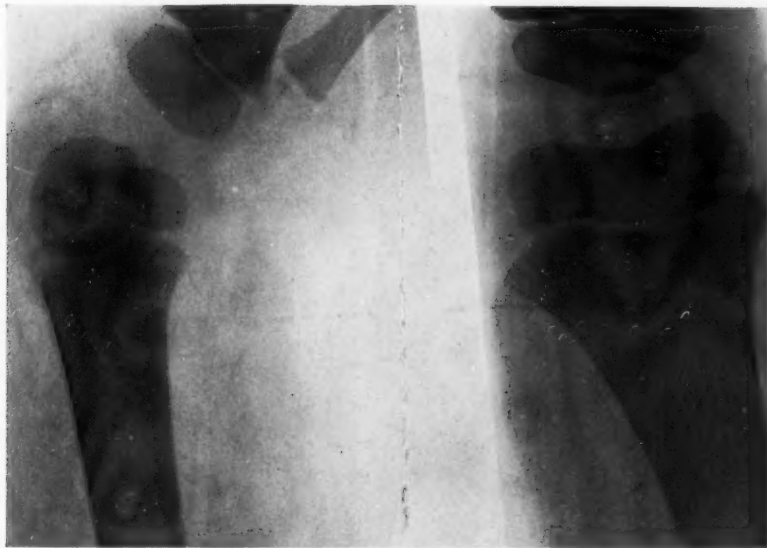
Case XVI. X-ray case three months later, showing apparent regeneration.
